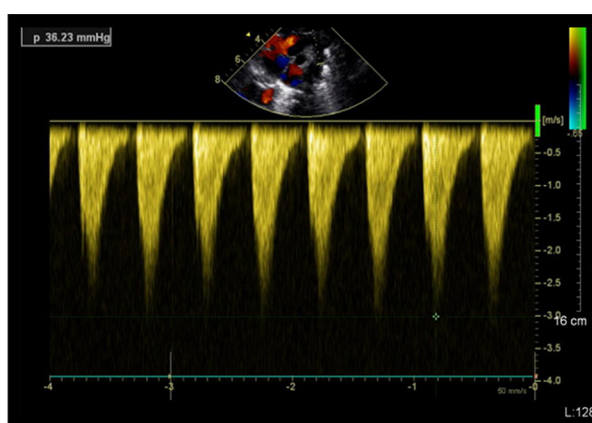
Transthoracic echocardiograms in suprasternal view in a 1-month-old (B) girl, showing high-speed flow in the CoA.
